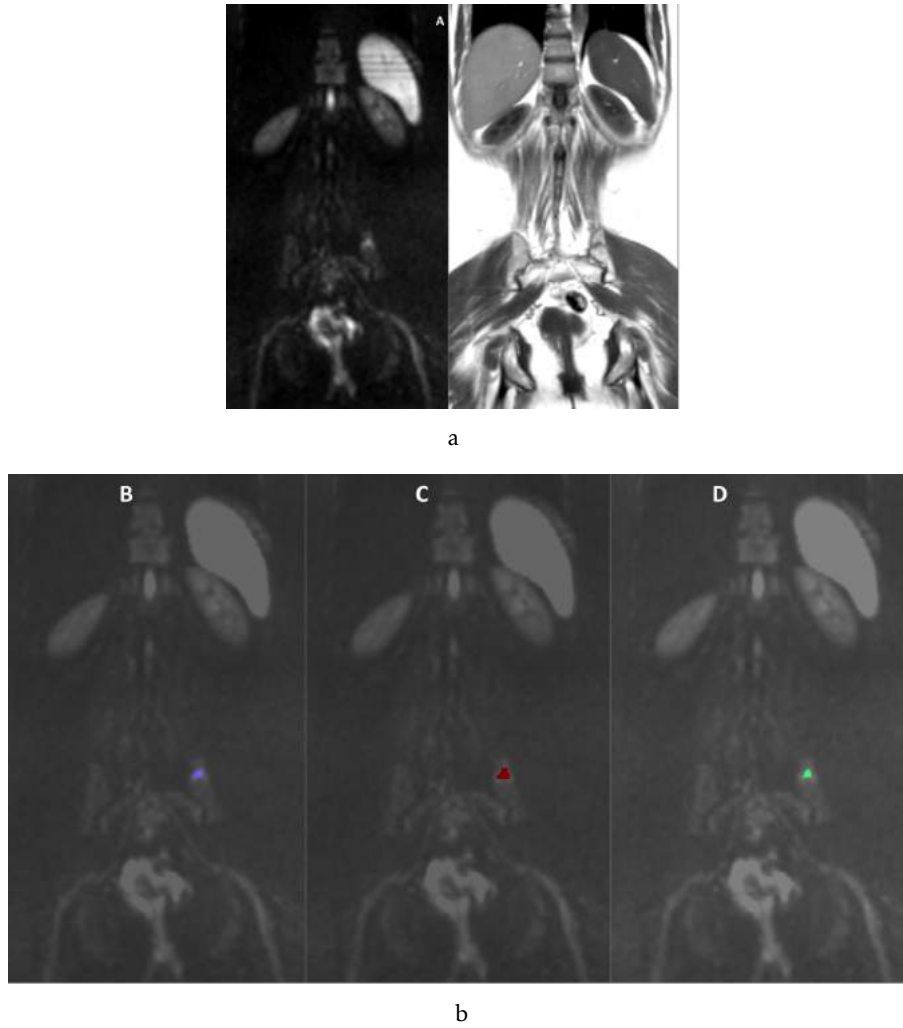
Side-by-side comparison of manual and smart segmentation of Case 7 (female). (a) Original DWI and T1w images: A show a representative zoomed coronal slice of 1000 s/mm² b-value DWI and T1w images. It is visible a small hyperintense on DWI and dark on T1w area on the iliac bone. (b) Segmentation: Sub-images B, C and D show E2, E3 and smart segmentation, respectively. The smart segmentation is referred to using just the outlier segmentation, using $k=3$ on 1000 s/mm² b-value image.
